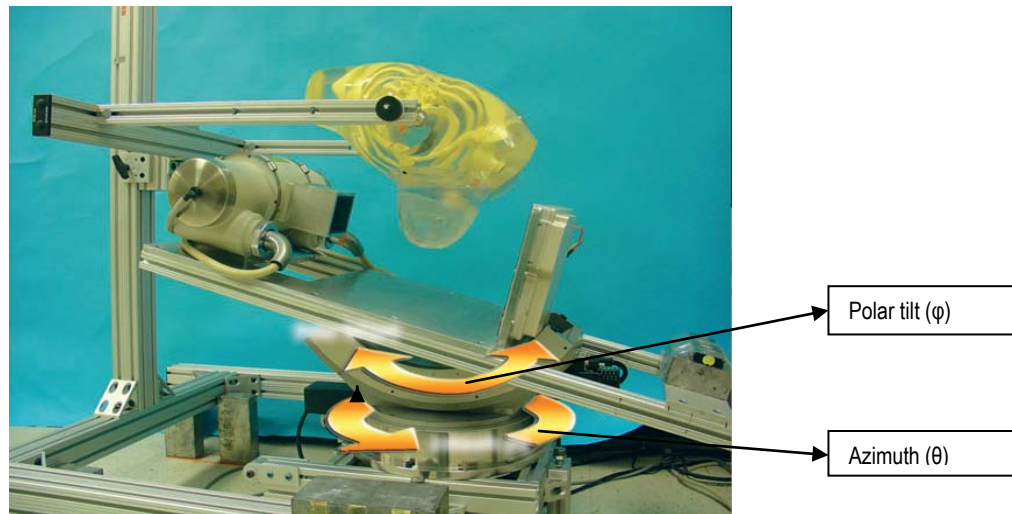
Dedicated breast CT gantry (developed at Duke University) (Glick 2007)
